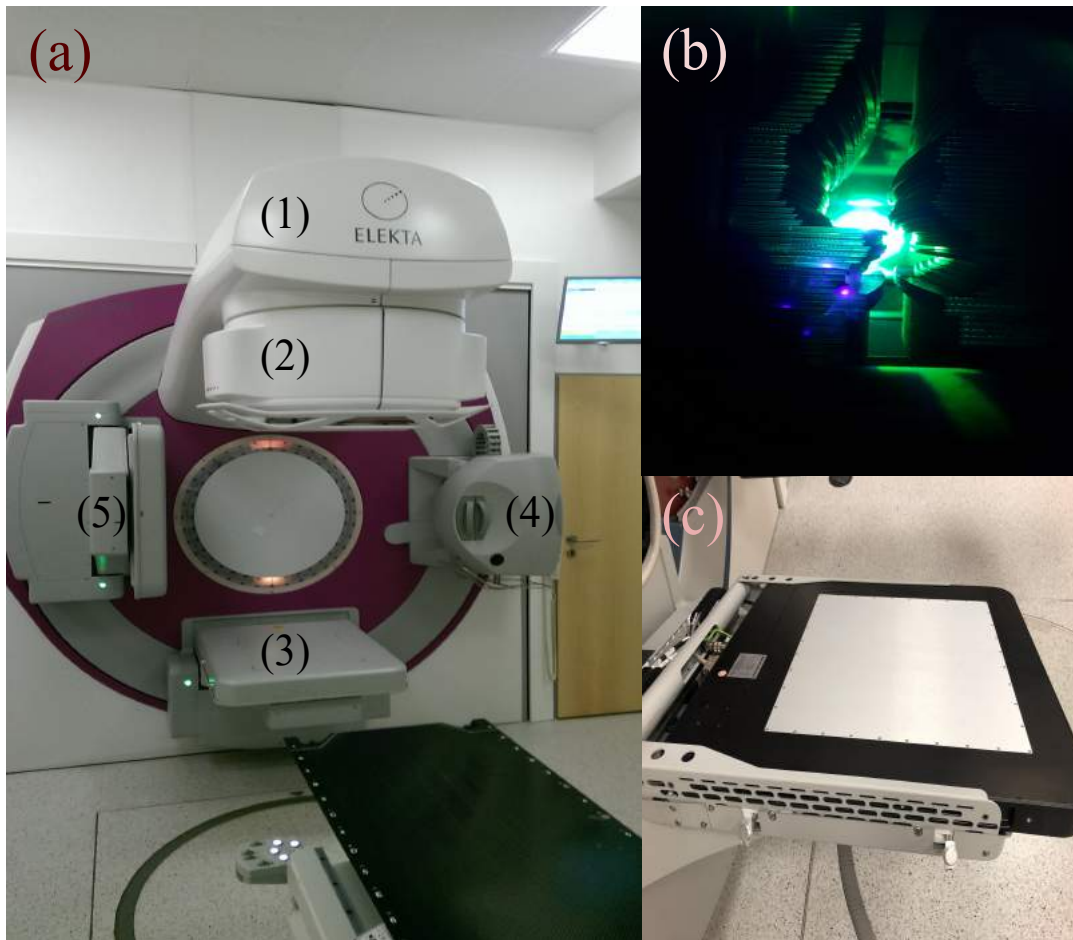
(a) ELEKTA linac components: (1) beam source, (2) linac head (includes MLC and jaws), (3) EPID, (4) X-ray source, (5) kV EPID. (b) A picture of the MLC defining the field shapes. (c) The EPID, without the plastic cover.
